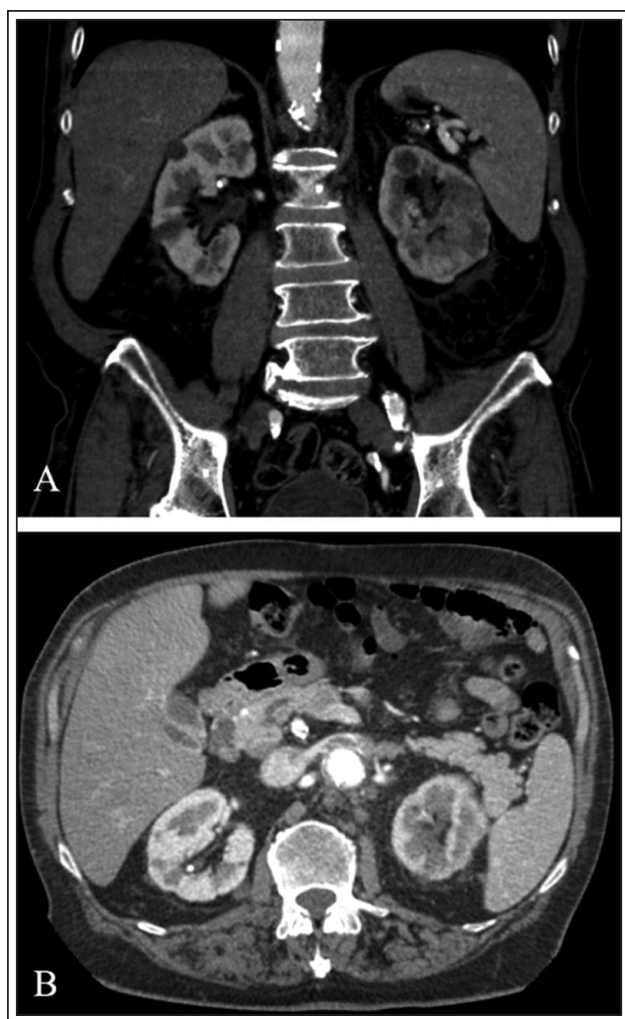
A) CT urogram demonstrating hypoenhancing lesion of left kidney. B) CT angiogram with heterogeneous appearance of left vein suggestive of thrombus.
